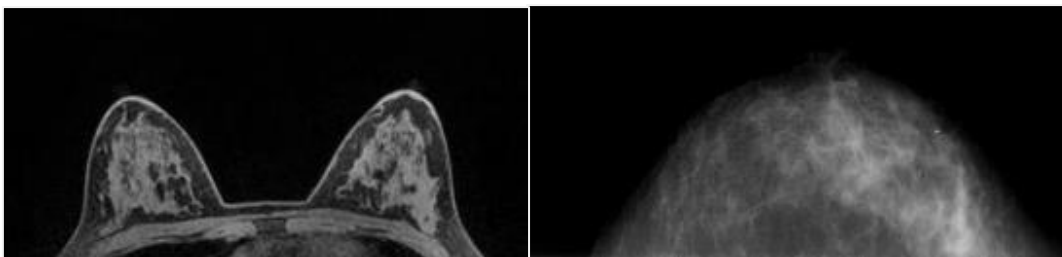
Examples of images resulting of an MRI exam (left) and a MG (right).
